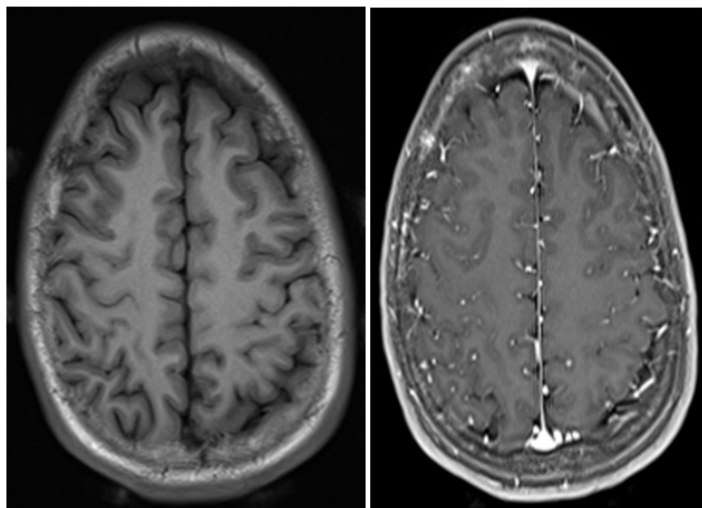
Two-month followup brain MRI. Pre- (A) and Post-contrast (B) axial T1-weighted images demonstrate resolution of the previous epidural hematoma and cephalohematomas with patchy T1 signal hypointensity and enhancement in the frontal calvarium, consistent with an evolving bone infarct.
